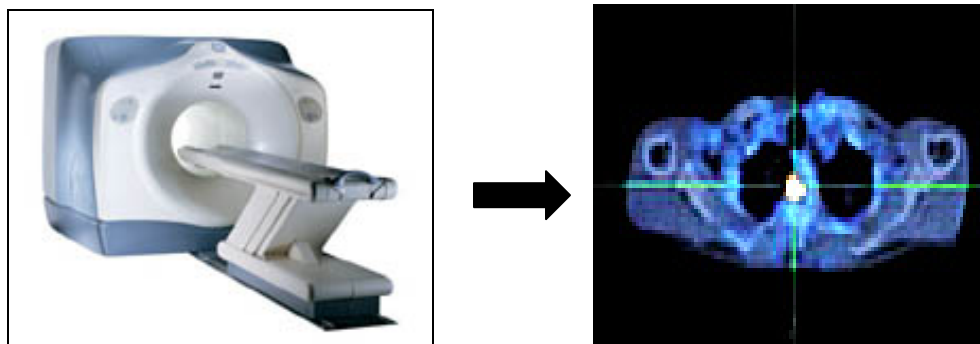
Hybrid PET/CT scanner on the left and PET/CT transaxial slice (through the lung) on the right. (Source: <http://www.wiproge.com/>)
